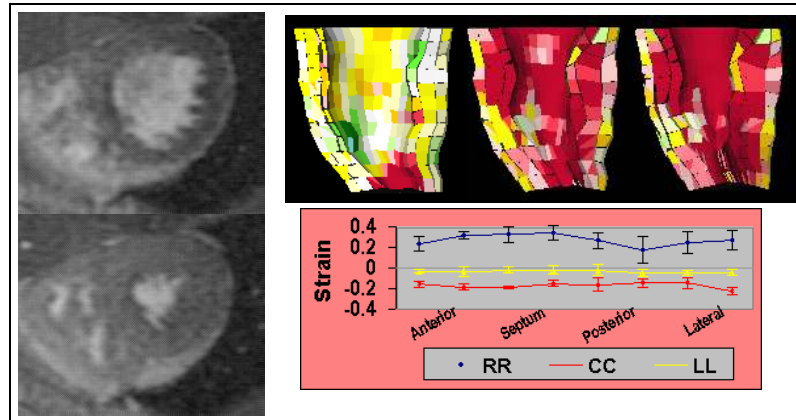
Human cine-MRI-derived results. Left: Magnitude breath-hold ED and ES images at a single slice level. Upper right: (see color scale in fig 7.11) radial strains at 3 long axis time points between ED and ES. Lower right: mean *cardiac-specific* strain values for $N = 3$ studies at mid-LV.
